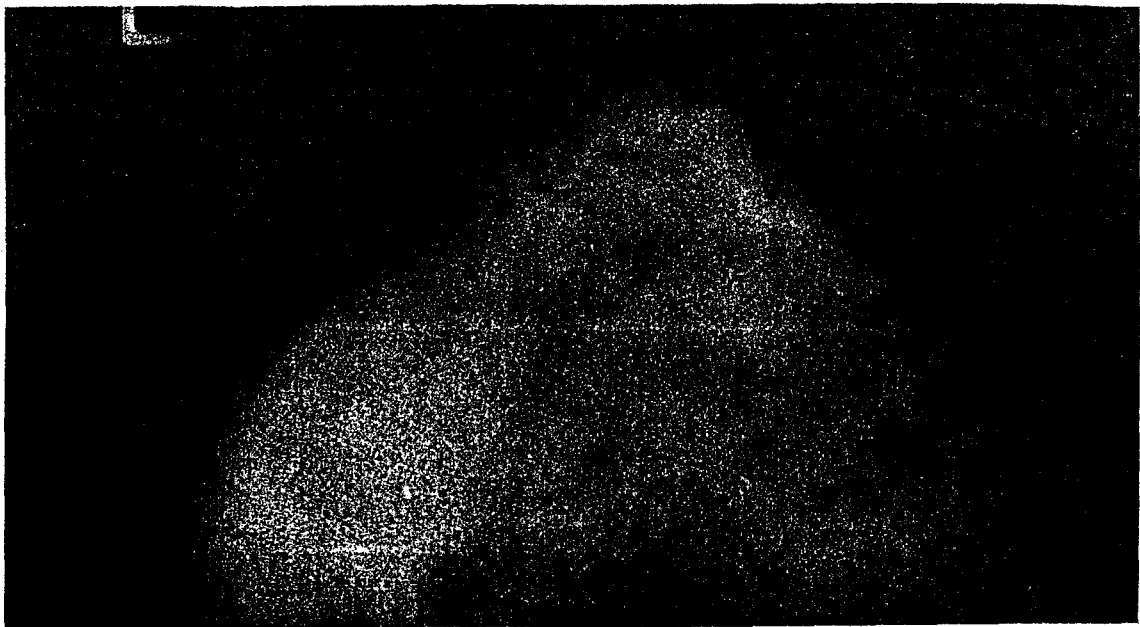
(a) Left breast, x-ray image.
